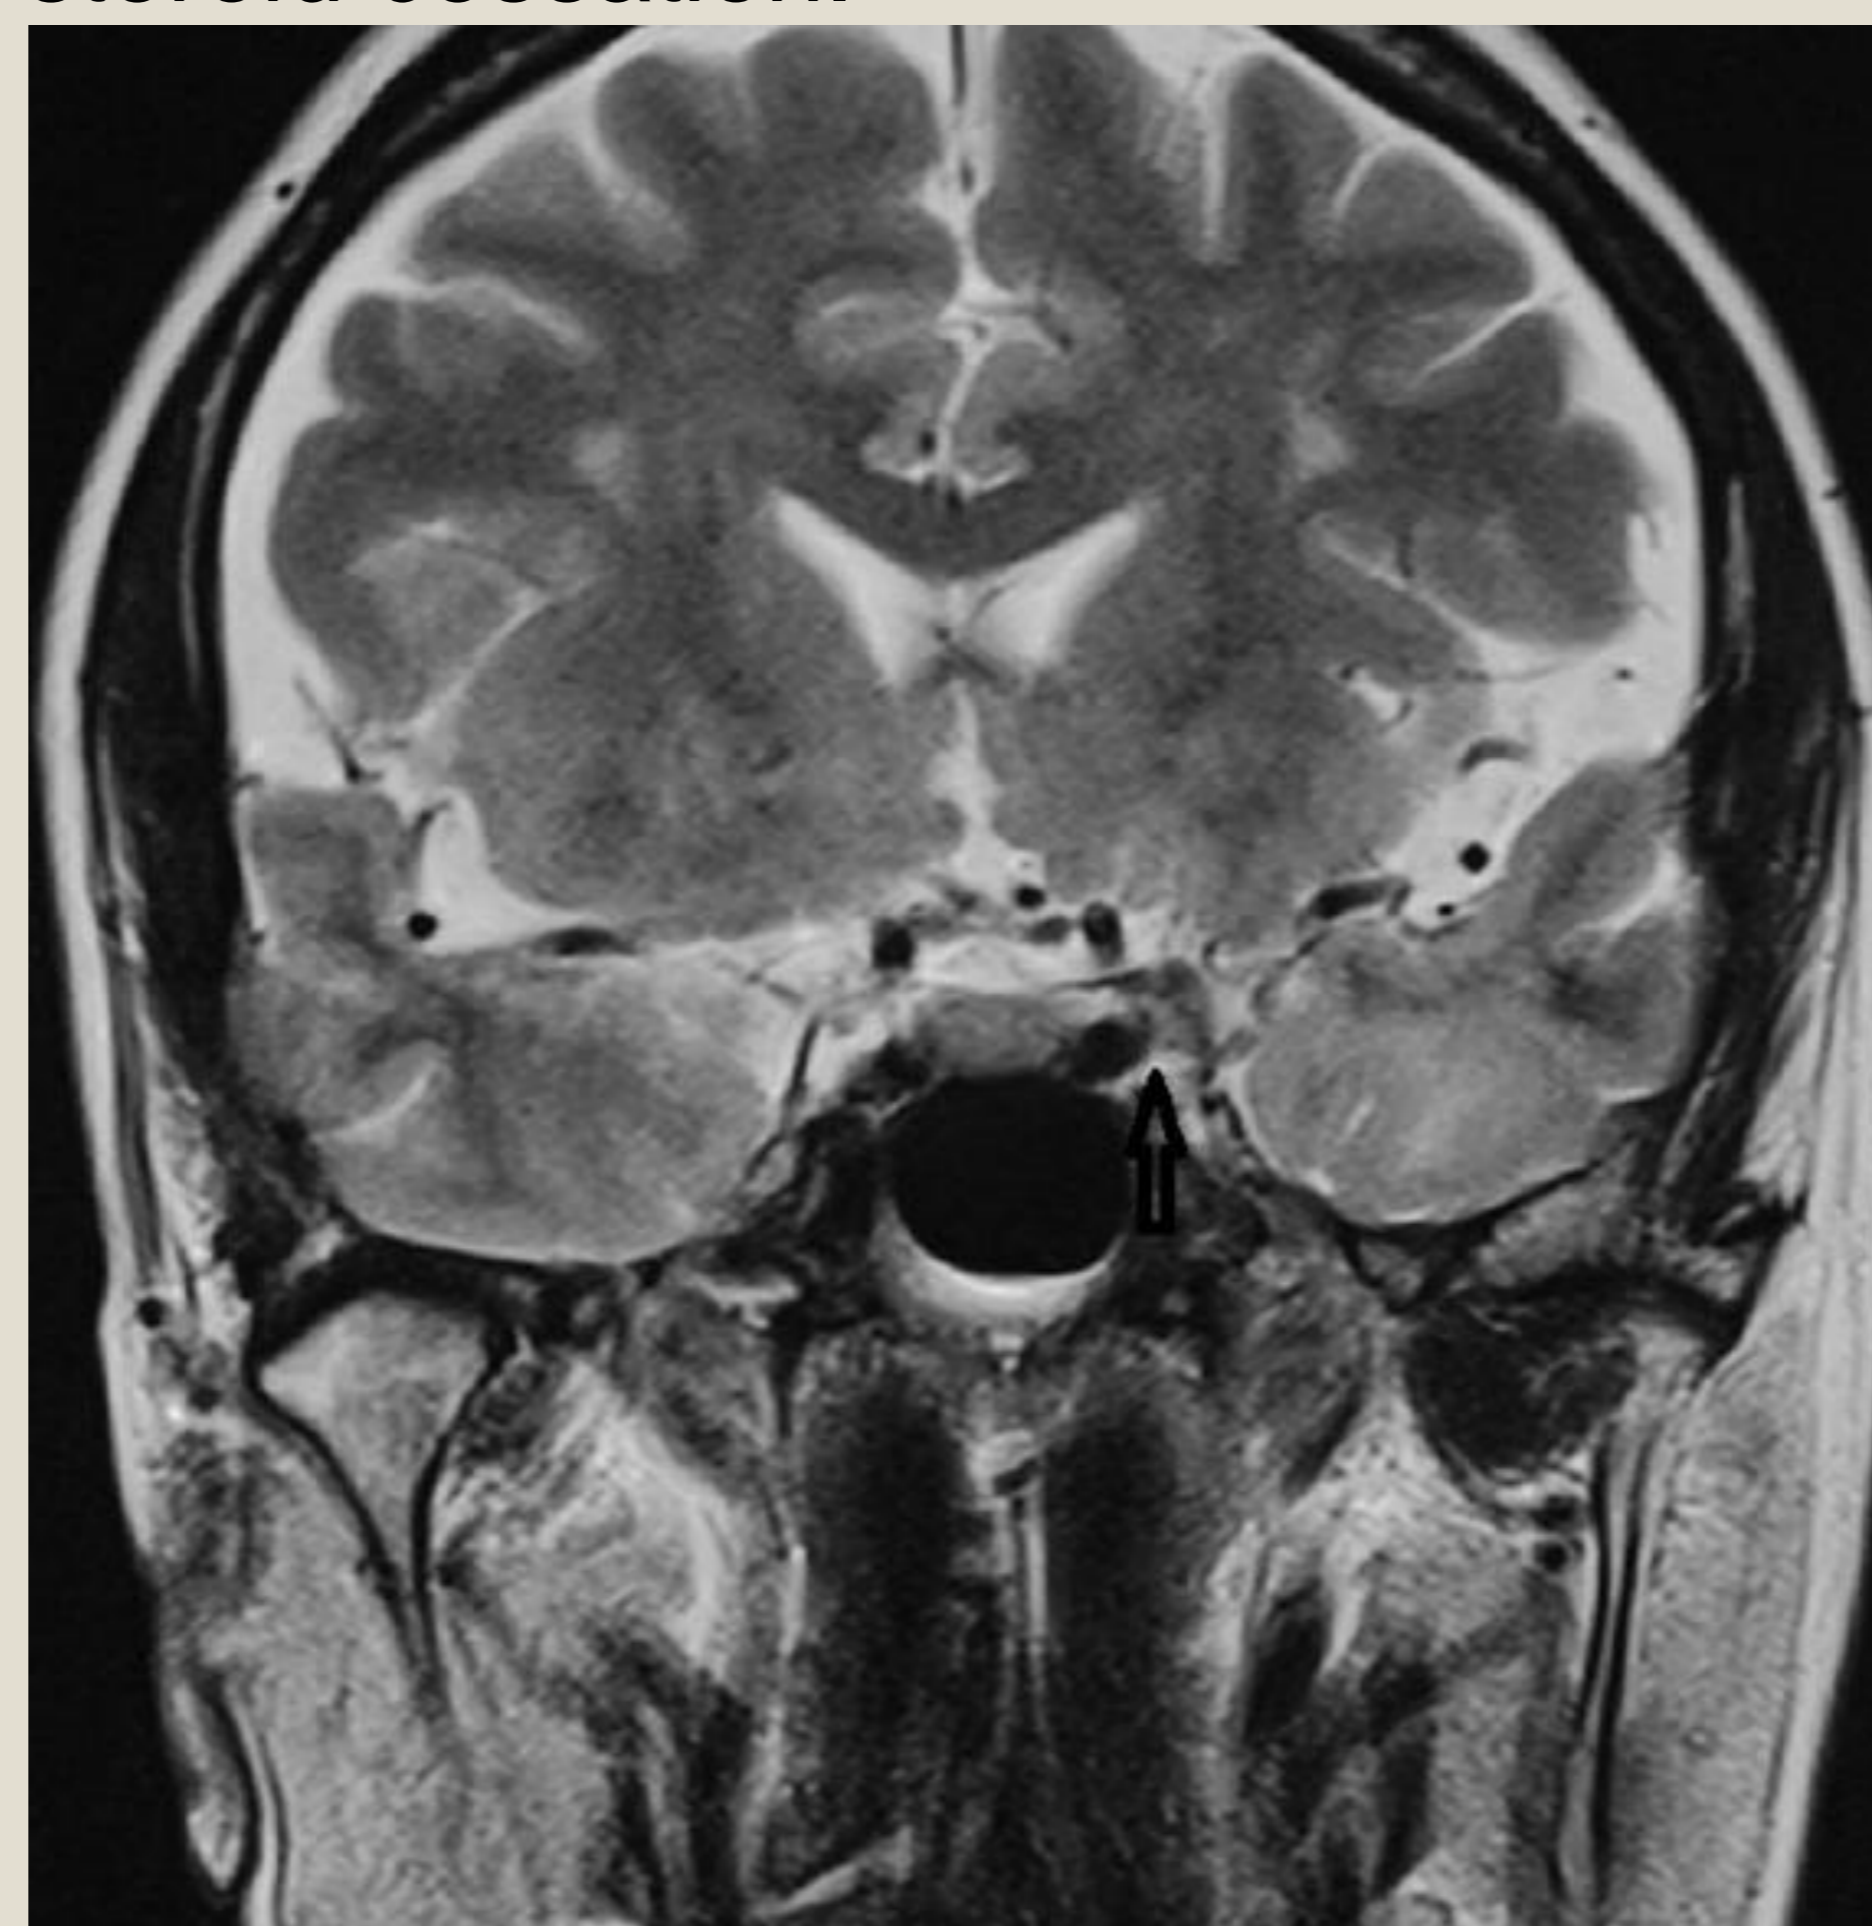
Tolosa–Hunt syndrome demonstrated by constructive interference steady state magnetic resonance imaging Wani NA¹, Jehangir M¹, Lone PA².
